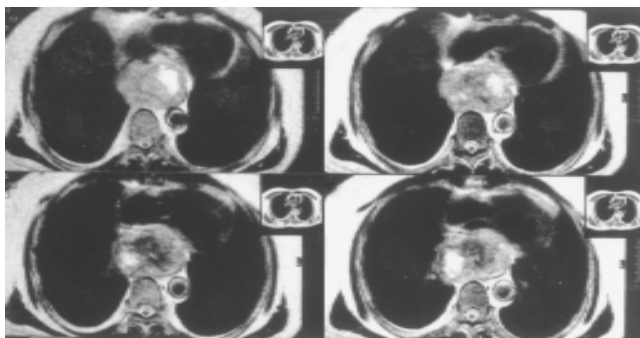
A 42-year-old male with giant esophageal leiomyoma. MRI image shows the tumor located in lower thirds of the esophagus. The size of tumor is 10 cm×10 cm×6 cm.
